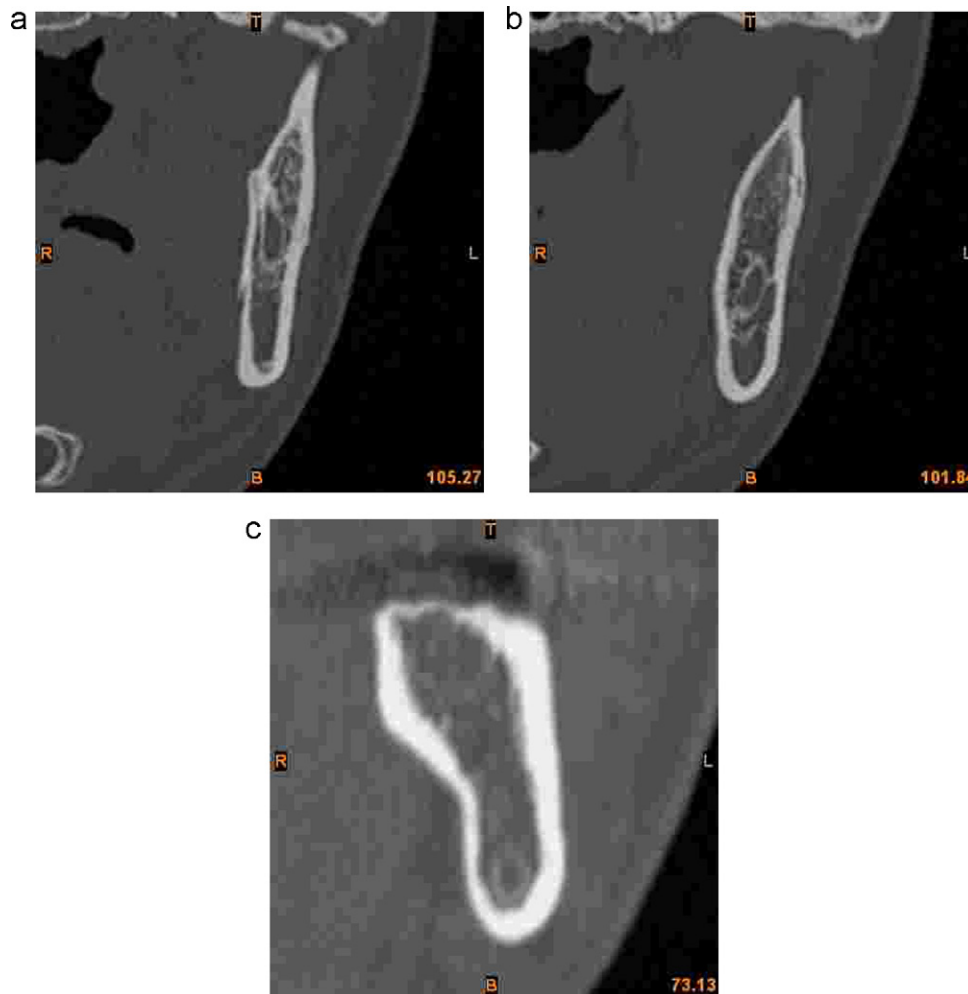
Coronal CT showing no proximity at both the buccal and lingual cortices at positions (a) X1, (b) X2 and (c) X3.
